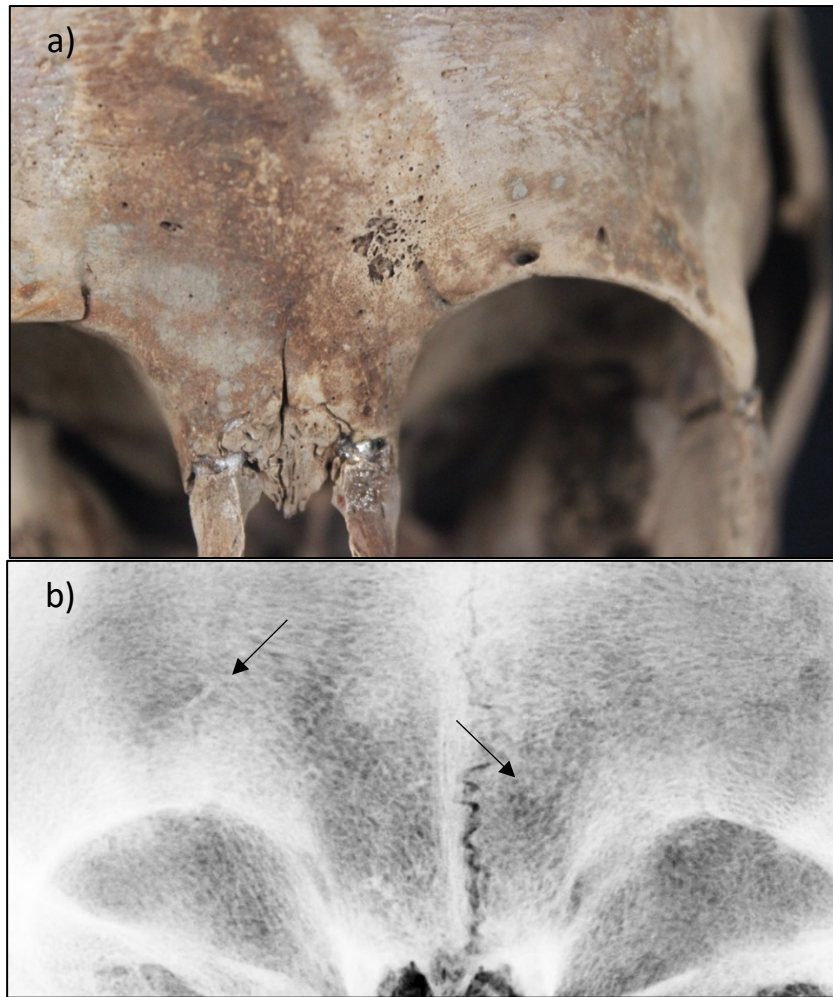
OL Grade 1 (Edo Period Japan, Cranium). a) The lesion is multifocal and coalesced with defined margins, no evidence of sclerotic reaction, and loss of both cortical and trabecular bone. b) Radiographs demonstrated two osteolytic regions with minimal bone response. The lesion on the left while macroscopically observable is faint radiographically, but multifocal lytic destruction is observable. However, the lesion on the right is more clear on the radiograph. As the lesion on the right does not penetrate the external cortex, these lesions are not due to taphonomic damage. Image: author's own.
